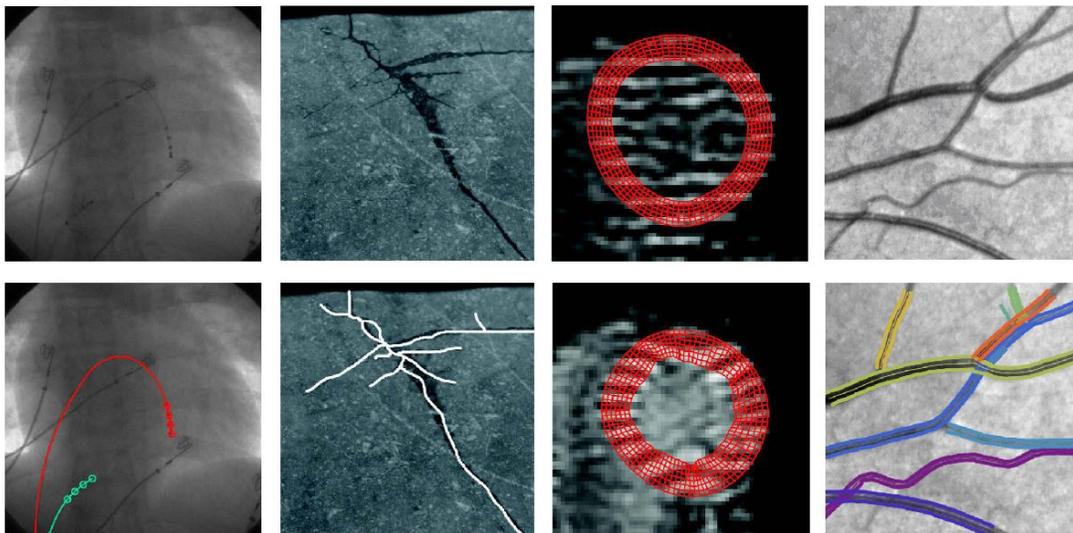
Various applications of (left-invariant) processing (detection) via scores. From left to right: 1. Detection of catheters in low-contrast X-ray fluoroscopy images via orientation scores, 2. Crack detection in granite stone slabs via orientation scores, 3. Quantification cardiac wall deformations via frequency scores, 4. Detection of the branching retinal vascular structure via (multiple scale) orientation scores outperforms the state of the art algorithms.
